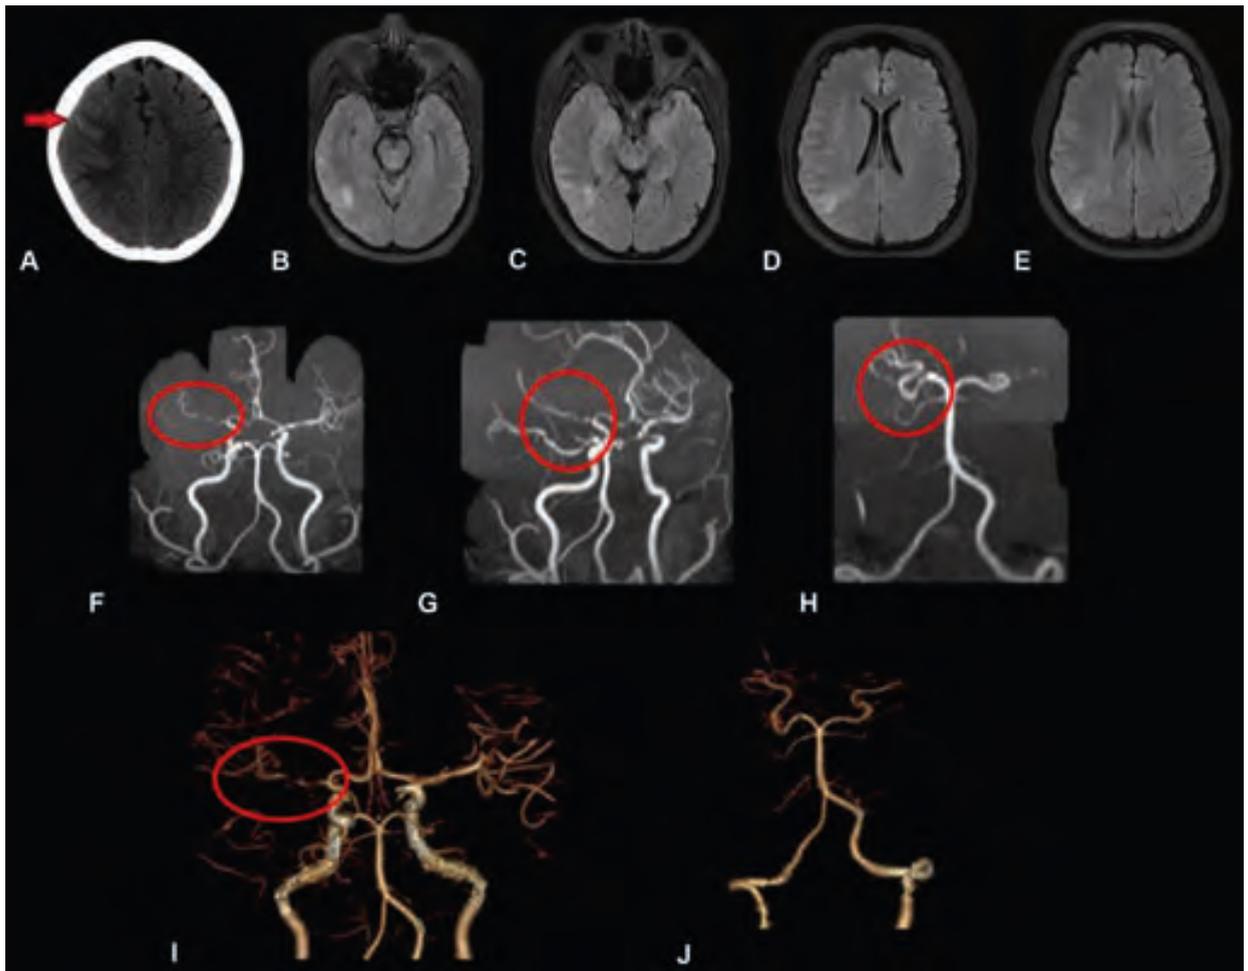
A 27-year-old right-handed woman, G1, P1 with history of gestational diabetes and pre-eclampsia had acute onset of “marching” left face and left hand numbness associated with slurred speech and nonpostural posterior head pain following delivery. Examination showed a blood pressure of 160/101 mmHg and bilateral pitting edema of her legs. Neurologic examination was unremarkable. Unenhanced CT (A) showed a focal cortical right frontal SAH (arrow). MRI (B, C, D, E) showed areas of abnormal signal intensities on the right posterior frontal and anterior parietal regions. MRA (F, G, H) demonstrated diffuse, bilateral areas of arterial narrowing and dilation more pronounced on the right middle cerebral artery (MCA) (oval and circles). CTA (I) corroborated areas of intracranial arterial narrowing (oval). Post-treatment CTA (J) showed resolution of the diffuse intracranial vasoconstriction. Final diagnosis was RCVS (postpartum angiopathy) in a pre-eclamptic patient.
